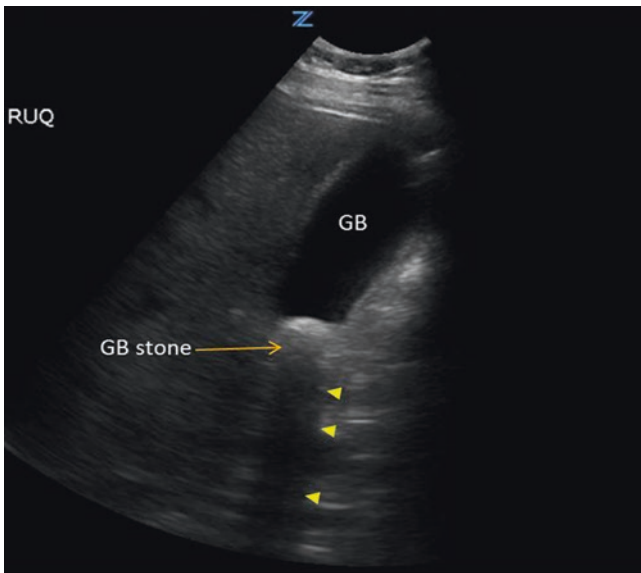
Ultrasound image of gallstone in the longitudinal plane. Impacted gallstone with posterior shadowing (*arrowhead*). Image courtesy of Pimpa Limphan-udom
